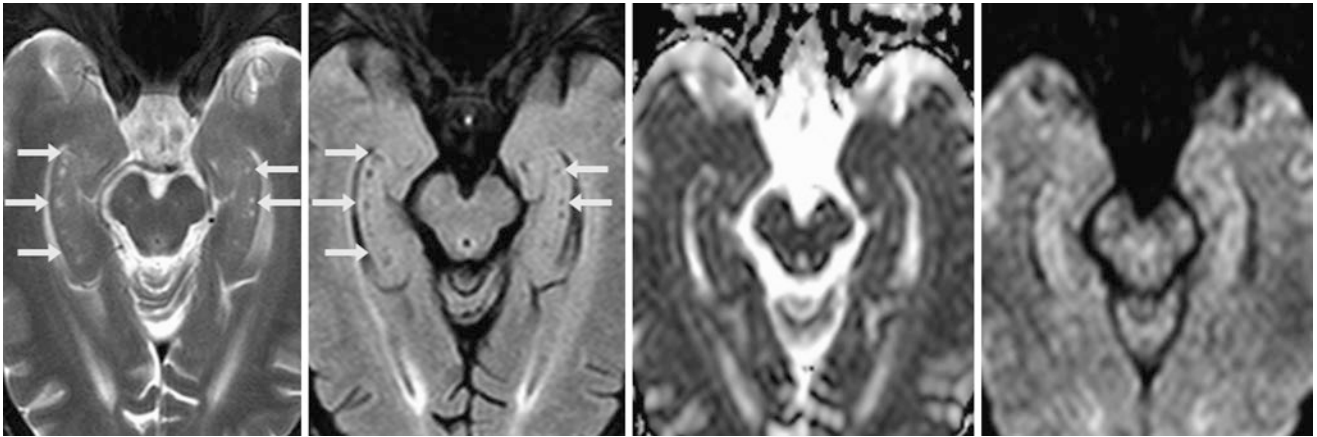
A 40 year old underwent a 1.5 T MRI axial T2WI (*left*) that demonstrated multiple bilateral tiny hippocampal cysts (*arrows*), which have a signal intensity akin to that of CSF on FLAIR (*left middle*), on ADC maps (*right middle*), and on DWI (*right*)
